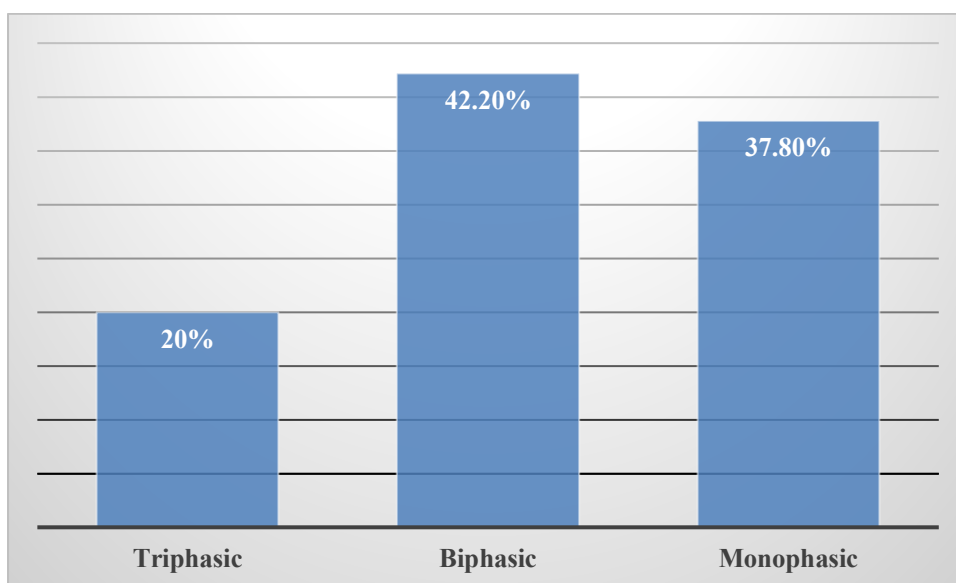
Visual Representation of Doppler Ultrasonography Findings (n = 180)
